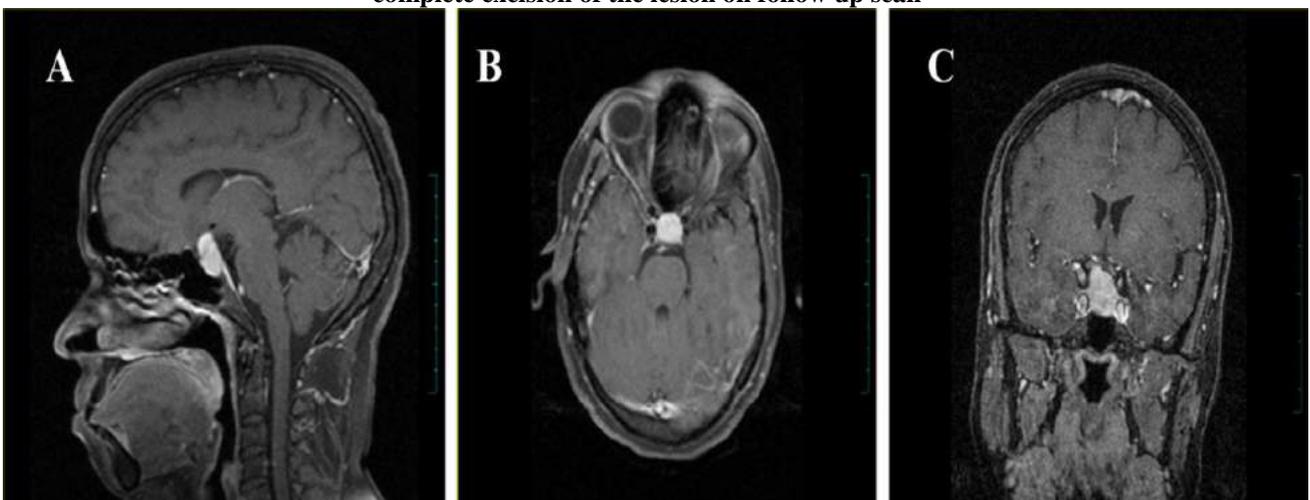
MRI BRAIN - Post Contrast Images: A - Sagittal View, B - Axial View and C - Coronal View showing homogenous post contrast enhancing lesion compressing the adjacent optic chiasma
